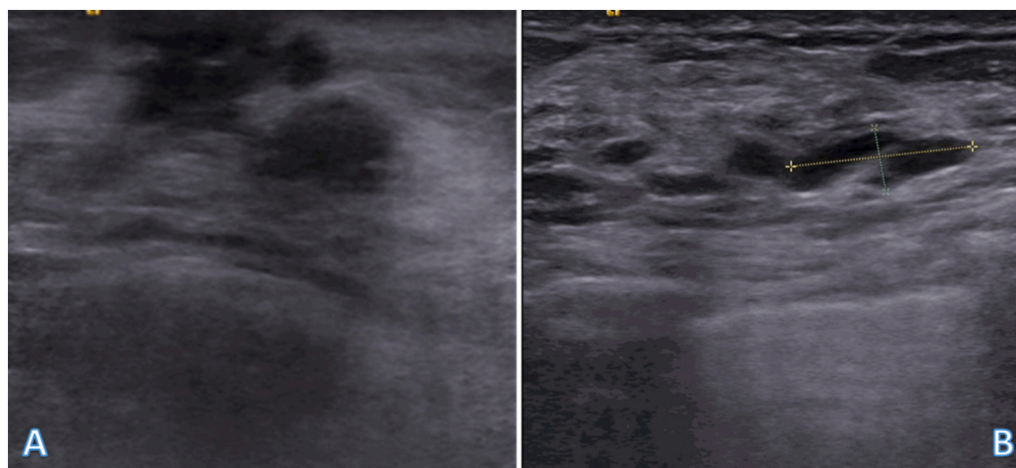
Ultrasound of the right axillary region showing (A) a 2.3×1.3 cm irregular hypoechoic mass invading the subcutaneous tissue containing small hyperechoic foci and (B) an oval shaped lymph node with hyperechoic fatty hilum and asymmetric focal cortical thickening surrounded by breast tissue.
